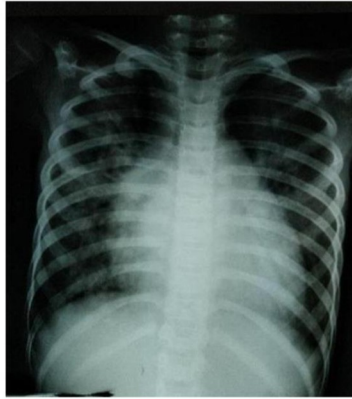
Chest Radiograph showed markedly enlarged heart with pulmonary congestion and/ or pneumonia. Diaphragm and sinuses were intact
